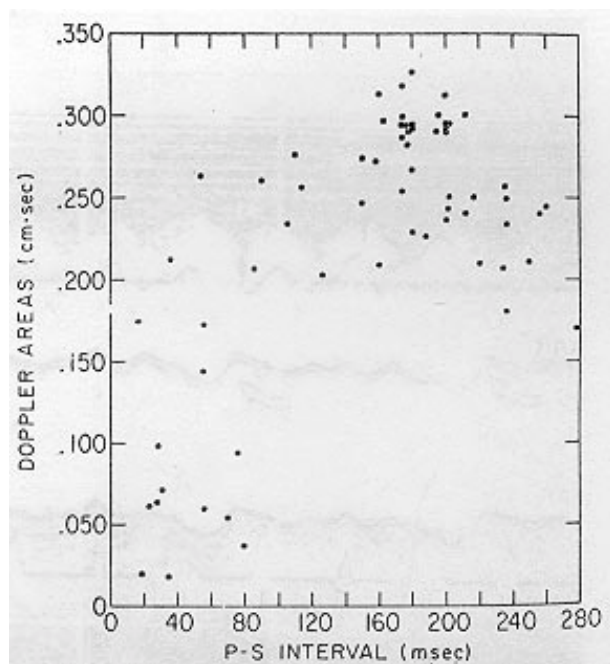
Relationship between Doppler areas and P-S intervals.
